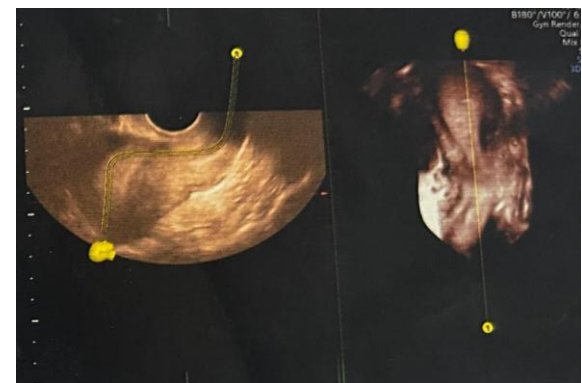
Three-dimensional ultrasonographic reconstruction showing a non-communicating functional rudimentary horn separate from the normal uterine cavity.
